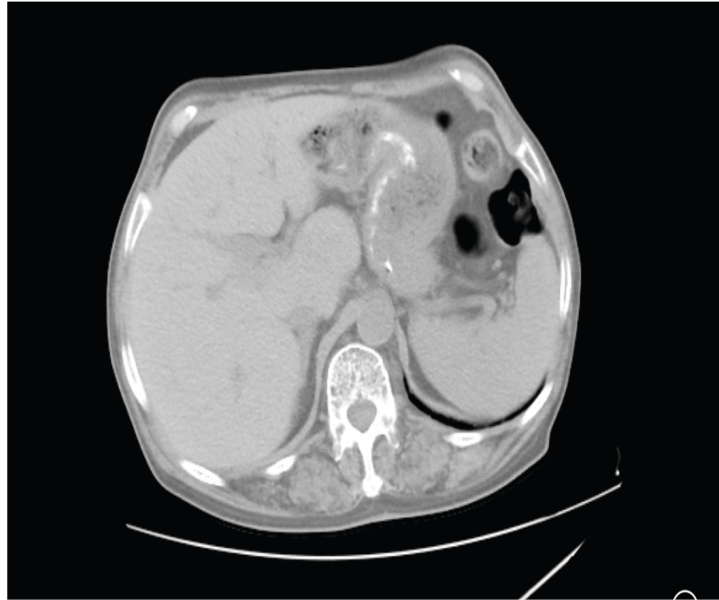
Enhanced CT before chemoradiotherapy.
